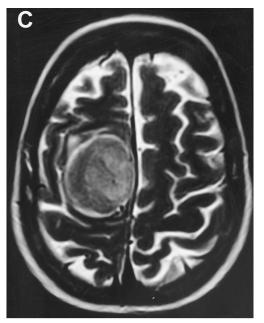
(A) Axial T_1 -weighted MRI scan of right frontoparietal parasagittal meningioma with homogenous enhancement typical of benign meningioma. (B) Coronal T_1 -weighted MRI showing meningioma filling the angle between falx and convexity dura, characteristic of parasagittal meningioma. Signal flow void near midline is consistent with patent superior sagittal sinus. Note relative lack of mass effect given large size of tumor, suggesting slow tumor growth over a long interval of time. (C) Axial T_2 , second echo image showing no edema in surrounding brain and thin rim of hyperintensity between tumor edge and brain, consistent with preserved arachnoid plane.
